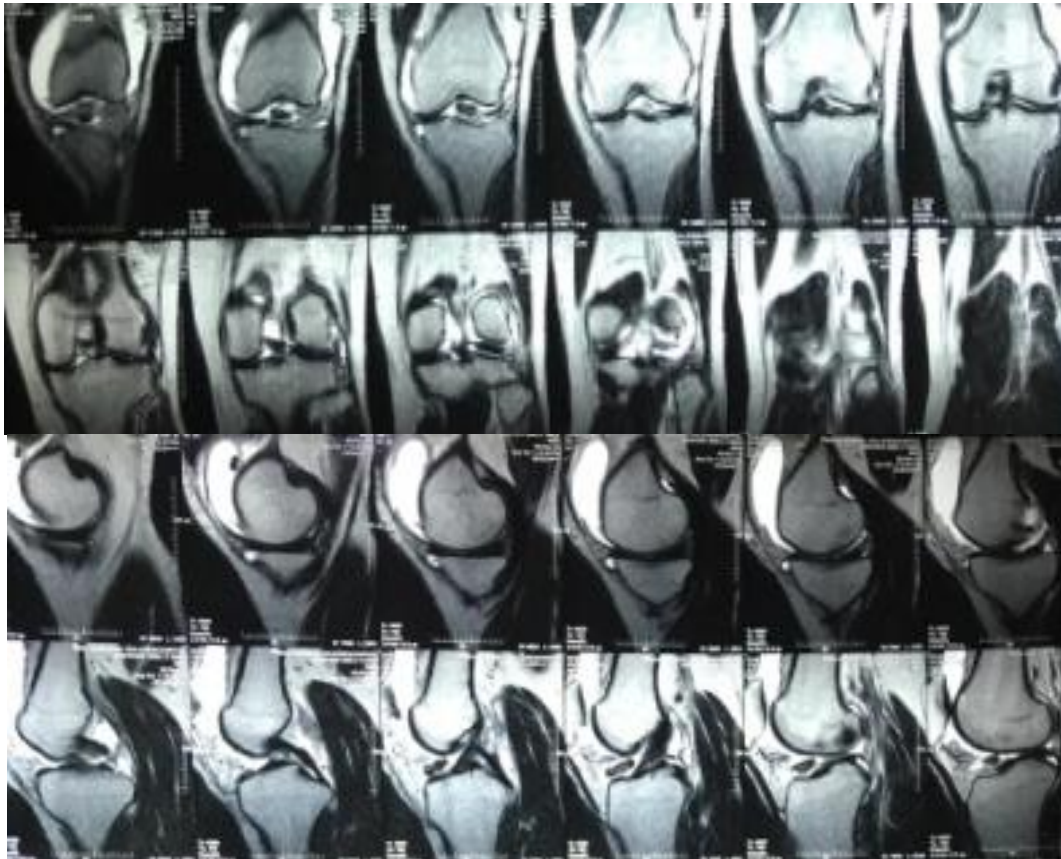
MRI scans showing loose bodies
